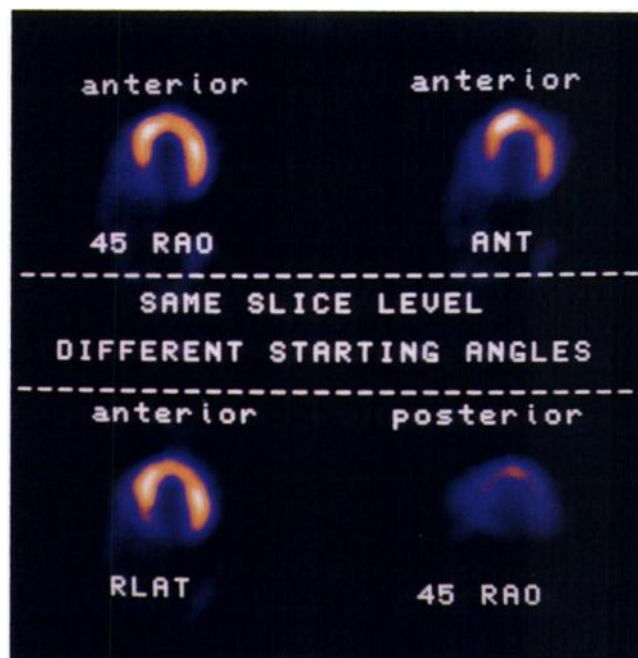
Effect of different 180° acquisition arcs on SPECT ^{99m}Tc -sestamibi image quality. The label above each image describes the 180° acquisition arc, and the label below describes the starting angle. Images have the lateral wall on the right and the septal wall on the left. (Top) Transaxial images with different starting angles and different acquisition arcs (anterior and posterior). RAO = right anterior oblique; ANT = anterior; RLAT = right lateral. (Bottom) Quantitative maximal count circumferential profiles from the images shown in Figure 2A. \diamond = RAO starting angle and anterior arc scan, \blacksquare = RLAT starting angle and anterior arc scan, \bullet = ANT starting angle and anterior arc scan, $+$ = RAO starting angle and posterior arc scan. Relative counts in the lateral wall [peak in profile curve between 90° and 180°] and the angular position and count activity of the hot spot on the ventricular septum (peak in profile curve between 180° and 270°) depend on the 180° acquisition arc. Differences in the image count profiles are due to the inability of the SPECT reconstruction program to compensate for the variable effects of attenuation and resolution in the projection view data.
